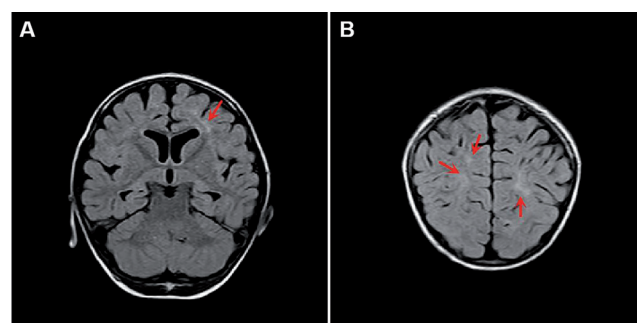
Brain MRI showing bilateral abnormal white matter signals in the frontal and parietal lobes (red arrows) and brain atrophy.
